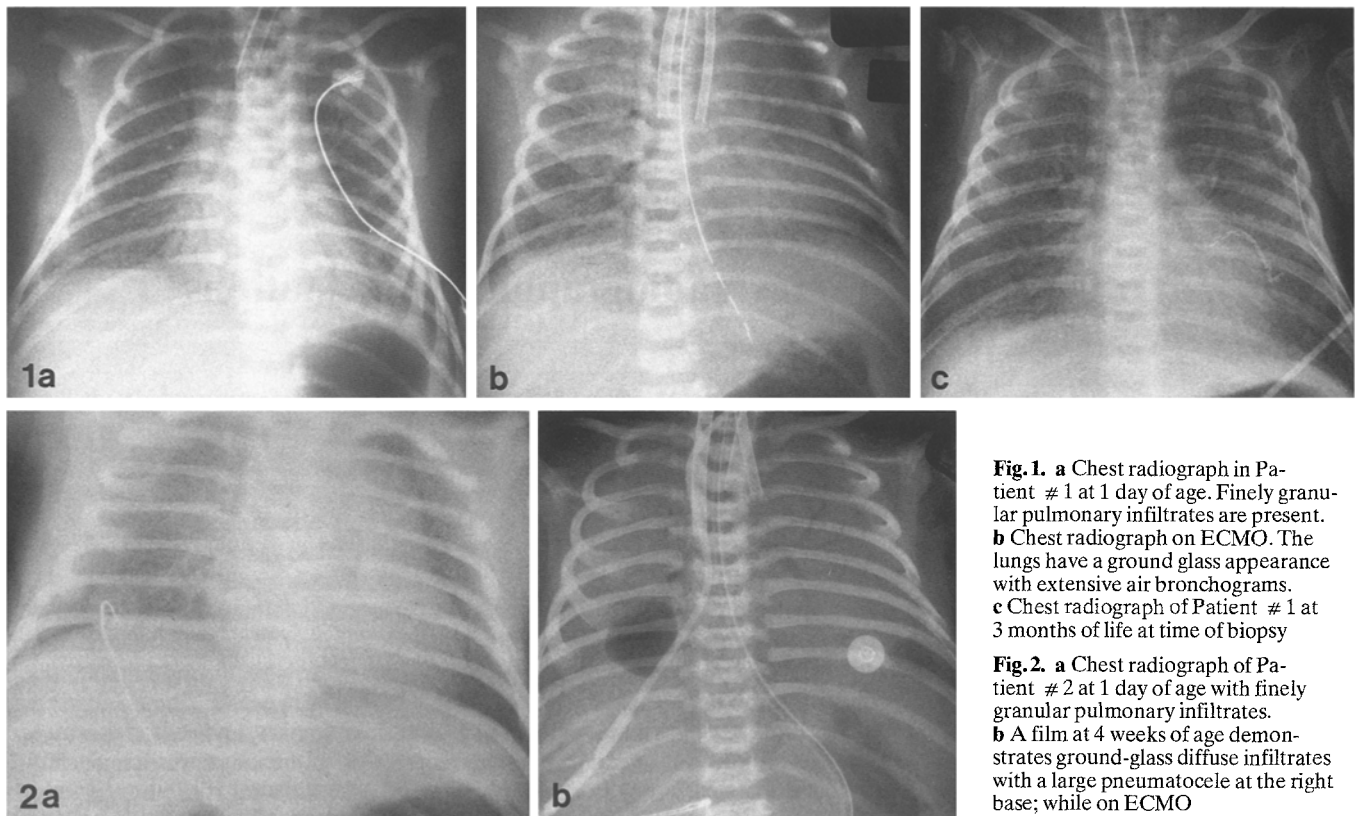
a Chest radiograph in Patient #1 at 1 day of age. Finely granular pulmonary infiltrates are present. b Chest radiograph on ECMO. The lungs have a ground glass appearance with extensive air bronchograms. c Chest radiograph of Patient #1 at 3 months of life at time of biopsy
